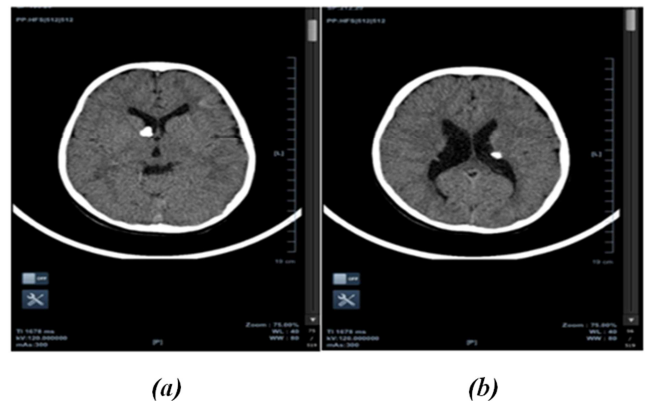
Subependymal nodule with calcification from head CT Scan. Nodules were found on (a) right and (b) left subependymal area near lateral ventricle.
